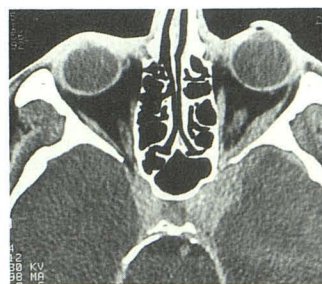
Contrast-enhanced CT scan 2 months after symptom onset. Contrast enhancement of wall of left cavernous sinus with extension intraorbitally is shown, as well as possible extension to the temporal convexity. Mild exophthalmos can also be seen.
